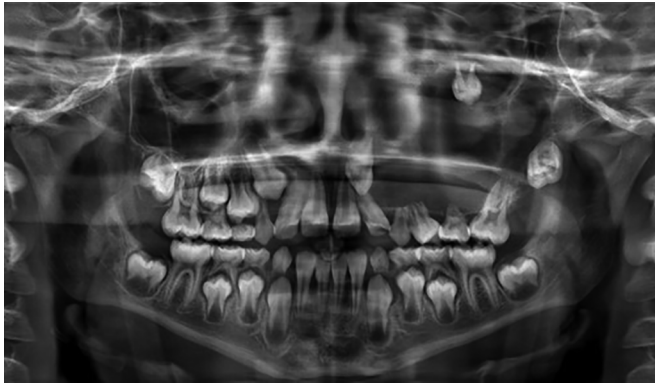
Panoramic radiographic image of the jaws showing radiolucent image inside the left maxillary sinus, with associated dental element.
